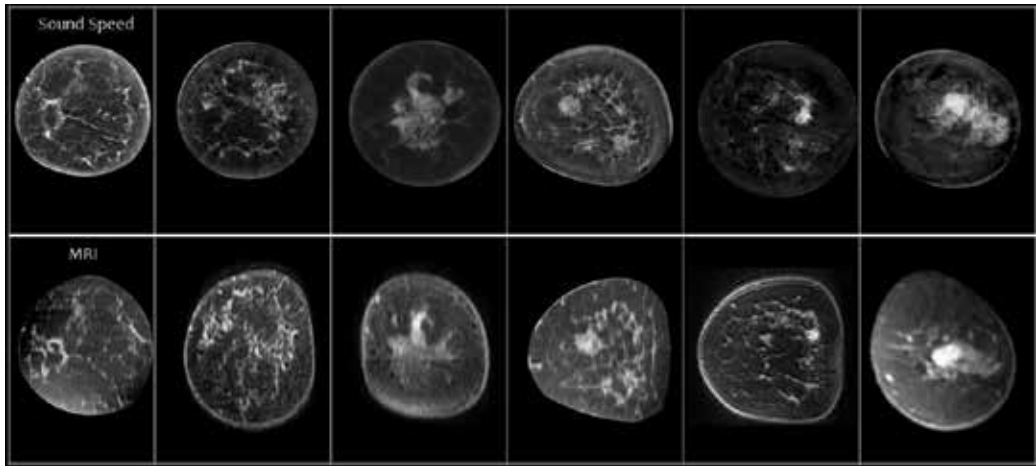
Top: Coronal UST sound speed images for six different patients. Bottom: Corresponding fat subtracted contrast-enhanced MR images.
